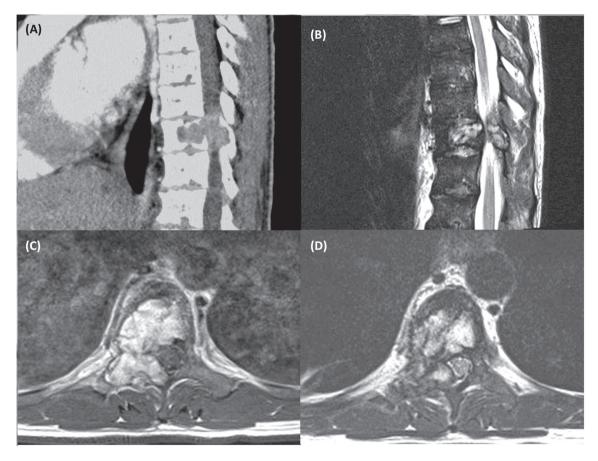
(A) Sagittal reconstruction of whole body CT scan in a 27-year-old woman with end-stage renal failure managed with hemodialysis, who presented to the neurosurgery clinic with a 3-month history of progressive low back pain radiating to the right lower limb and progressive paraparesis over the prior week. An osteolytic space-occupying lesion is seen at T10. (B) Sagittal T2-weighted MRI. (C) axial T1-weighted MRI with gadolinium, and (D) T2-weighted MRI demonstrate marked cord compression.
